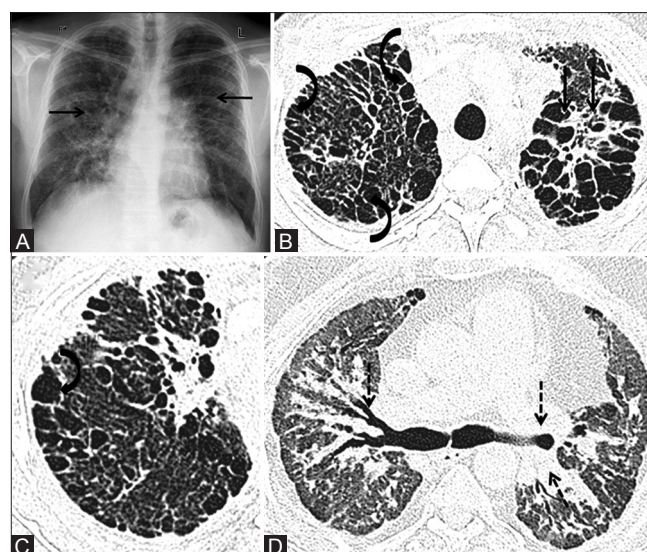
(A-D): Sarcoidosis with fibrocystic changes (A) Chest X-ray (CXR) of patient with sarcoidosis shows bilateral parahilar fibrotic opacities extending preferentially to upper and mid zones (black arrows). (B) Axial high resolution computed tomography (HRCT) image (lung window) in another patient shows peripheral subpleural honeycombing in bilateral upper lobes (curved arrows) alongwith fibrocystic changes in left upper lobe (solid arrows). (C) Magnified view of right hemithorax showing honeycombing with layering of cysts (curved arrow). (D) Axial HRCT image (lung window) in another patient shows parahilar fibrotic changes with bilateral central bronchial distortion and bronchiectasis (dashed arrows)
